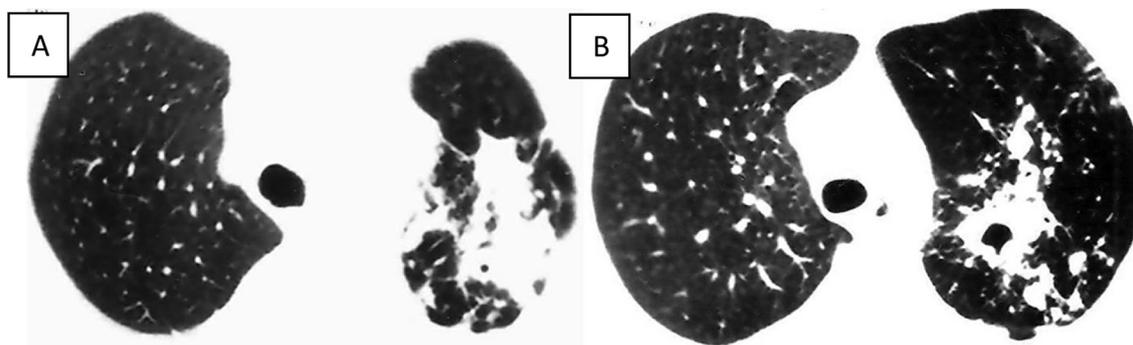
A and B: Contrast-enhanced high resolution computed tomography (CECT) of the thorax, showing patchy airspace consolidation associated with necrosis, cavitation. Peri-bronchial centrilobular nodules in the apical segment of left lower lobe along with a large lobulated airspace opacity in apicoposterior segment of left upper lobe with surrounding small patchy fibrotic nodules are also seen.
